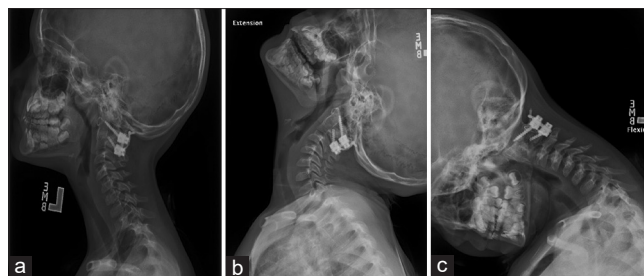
Follow-up cervical x-ray neutral (a), extension (b), and flexion (c) dynamic films at 6 years, showing C1-C2 posterior spinal instrumentation and fusion. Hardware is intact. No evidence of screw failure or dynamic instability. The vertebral body heights are maintained
